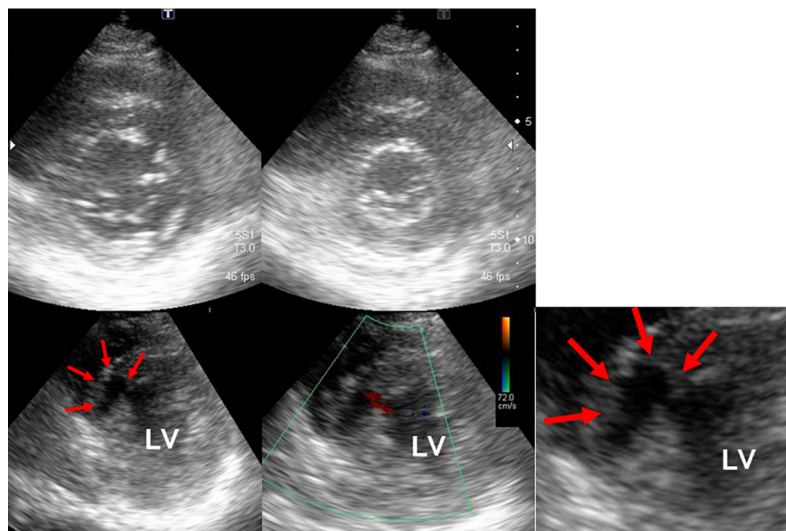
Transthoracic echocardiography at admission. Echocardiogram revealed normal ventricular contraction and a saccular type ventricular septal laceration (7.2 mm × 13.3 mm) with an influx blood flow without septal shunt flow. LV, left ventricle.
